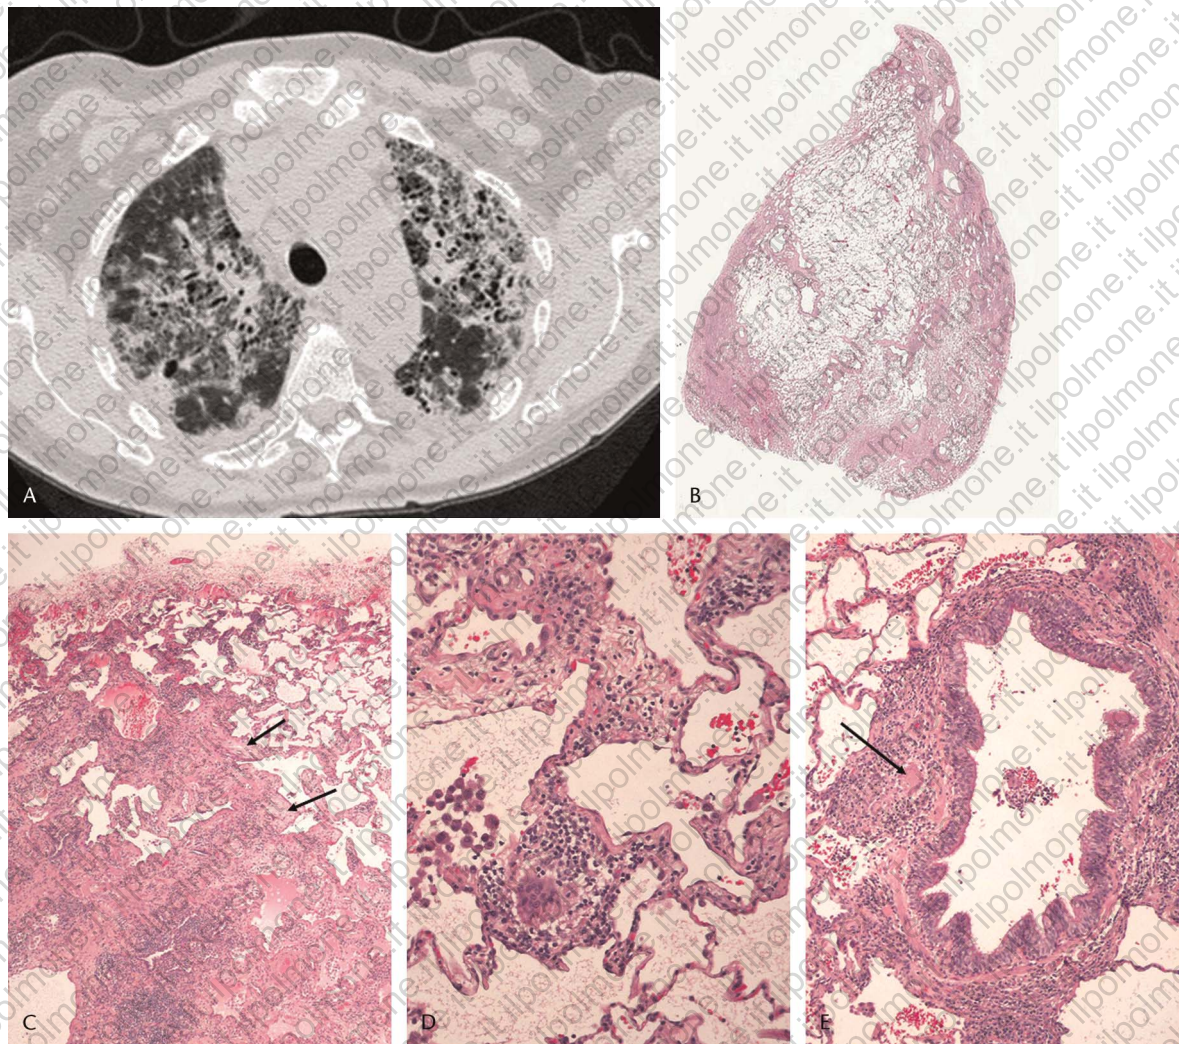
Chronic HP caused by mold exposure (case no. 1). A, High-resolution CT at the level of the aortic arch shows extensive bilateral upper lobe reticulation and honeycombing. Also present are a few poorly defined nodular opacities. The fibrosis in this case was predominantly upper zonal. B, Low power view of biopsy showing peripheral fibrosis with architectural distortion in a pattern resembling UIP. C, Higher power view of fibrotic area showing dense irregular fibrosis and fibroblast foci (arrows), mimicking UIP. D, Subacute HP-like area with an isolated interstitial giant cell and surrounding chronic inflammation. E, Membranous bronchiole with surrounding chronic inflammation and a giant cell (arrow). This image also show a pattern typical of subacute HP. a+
